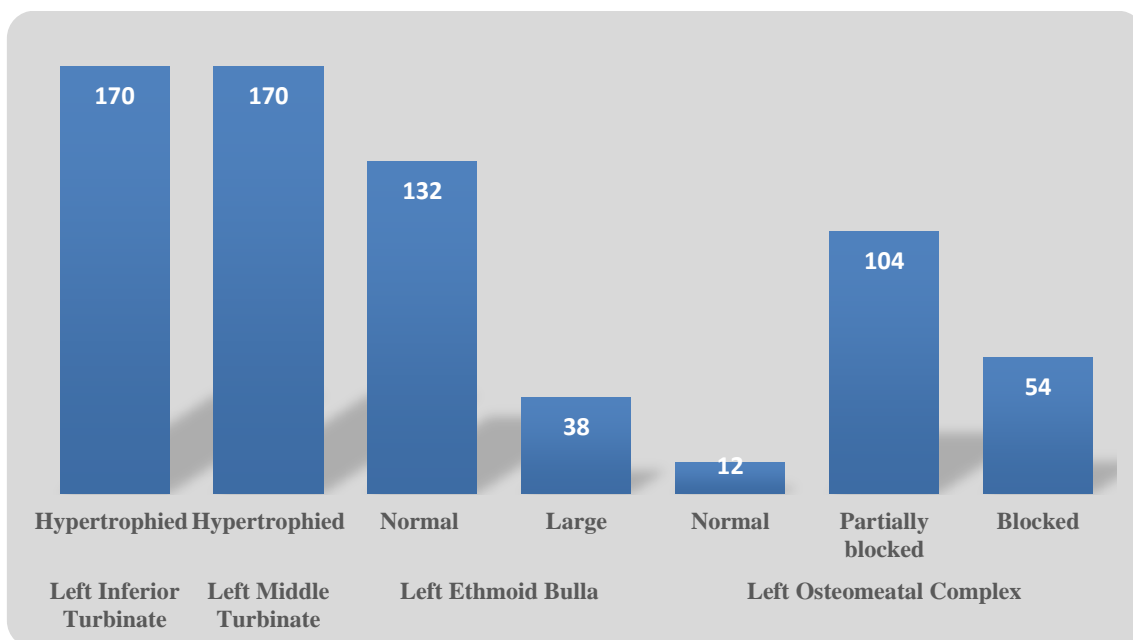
CT finding on left side of nose among rhinosinusitis patients
